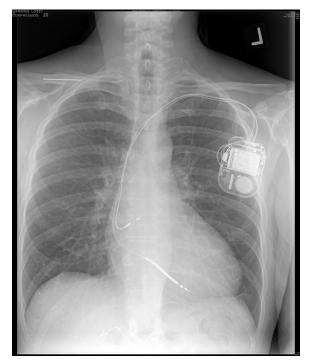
Radiographic image of the original implantable cardioverter-defibrillator system in the anterior-posterior projection.
